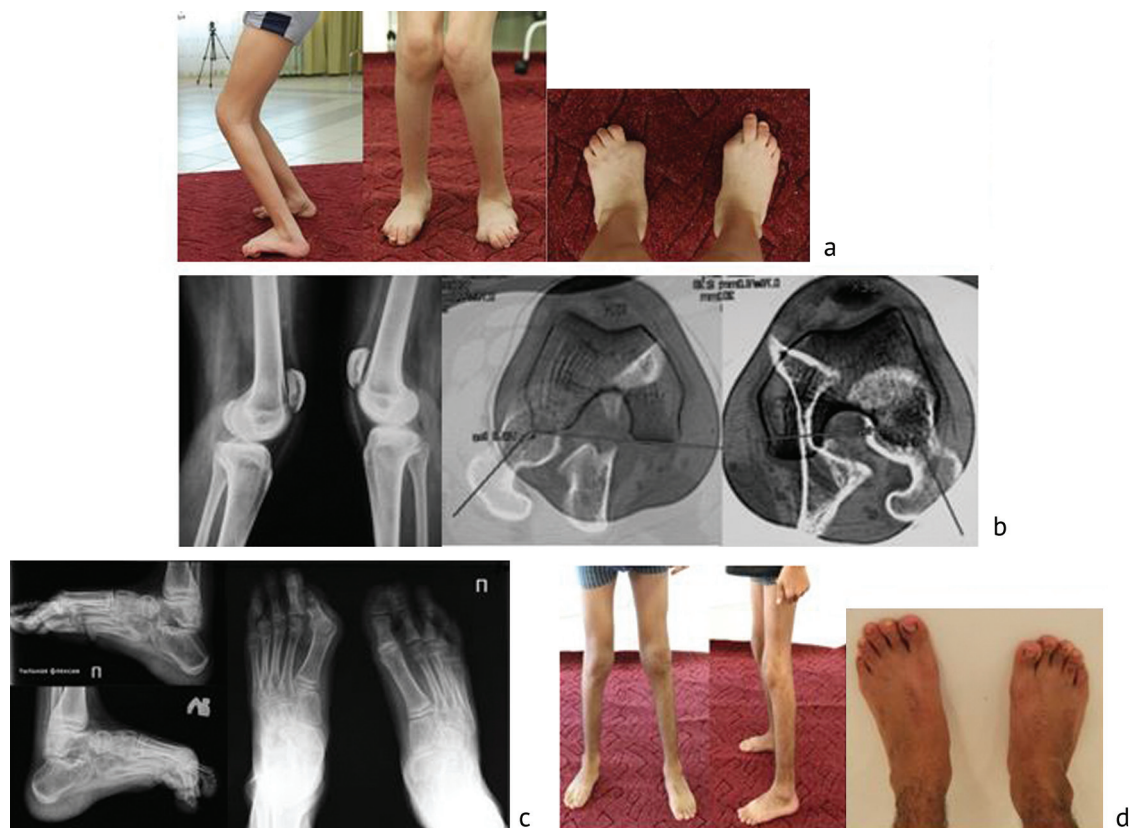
Patient D., 18 years old, GMFCS level II, had previous “staged fibrotomies”, after which he developed weakness of the triceps muscles of the lower legs, excessive dorsal flexion of the feet and secondary flexion contractures of the knee joints: a – photo of the lower limbs before the operation; b – radiographs of the knee joints and CT of the femurs showing the pathologically high position of the patella, torsional deformities of the femurs; c – radiographs of the feet; d – photo of the patient's lower limbs one year after performing bilateral intervention involving a supracondylar detorsion extension osteotomy of the femurs, bringing the patellae down, shortening of the Achilles tendon, and transfer of the long peroneal muscle to the calcaneal bone, arthrodesis of the first metatarsophalangeal joint
